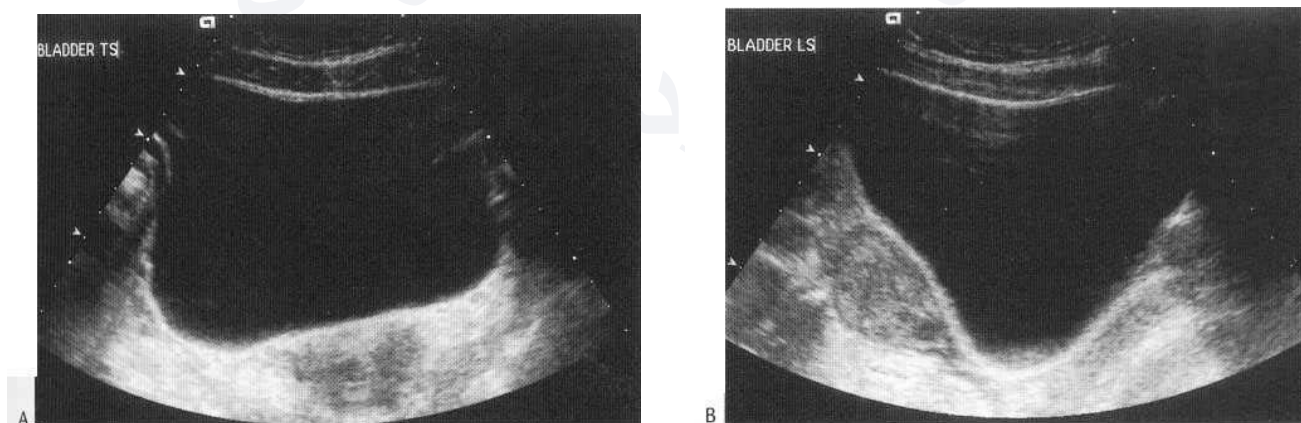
Normal bladder ultrasound; note the thin smooth wall and the shape approximating to a rounded-off square in the transverse view (A) and a rounded-off triangle in the sagittal view (B).
